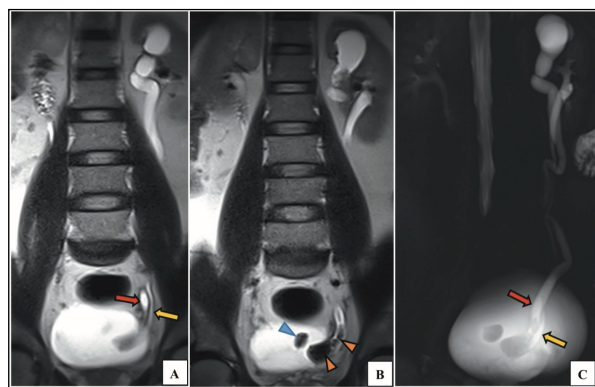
(A-C): MR urography images. Coronal T2W (A and B) and oblique thick slab T2W (C) MR images show complete duplication of the left collecting system with a calculi seen as T2W filling defects (orange arrow heads) within the ureterocele and in the distal ureter of the upper pole moiety causing hydroureteronephrosis. An intravesical calculus (blue arrow head) is also seen. The lower pole moiety (yellow arrows) is seen to drain into the bladder inferior and anterior to the upper pole moiety (red arrows) clearly represented in the thick slab images.
